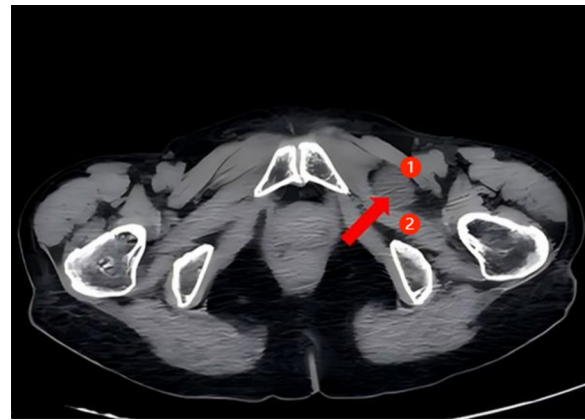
① pectineus and ② obturator externus. The axial computed tomography image shows the herniated contents located between the left pectineus muscle and the obturator externus muscle, as indicated by the arrow
